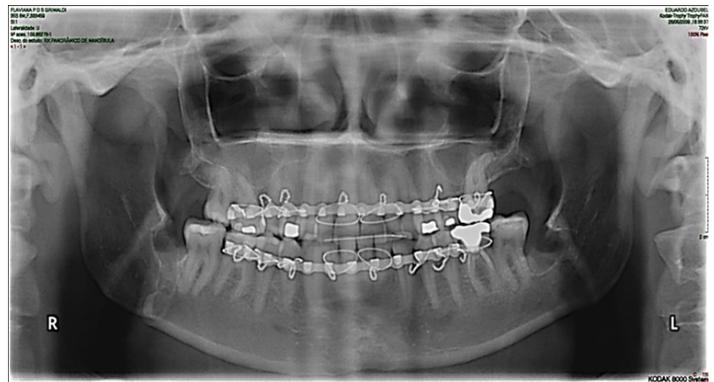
Post-extraction panoramic radiograph confirming the mandibular fracture, showing minimal bone displacement.
